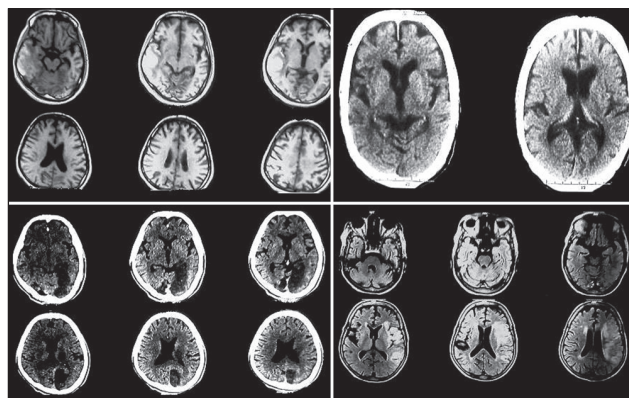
Magnetic resonance imaging (MRI) showing bilateral temporal lobe involvement in herpes simplex; computed tomography (CT) brain showing the acquired immunodeficiency syndrome demetia complex; CT brain showing left middle cerebral and posterior cerebral artery territory infarct; MRI showing progressive multifocal leukoencephalopathy
